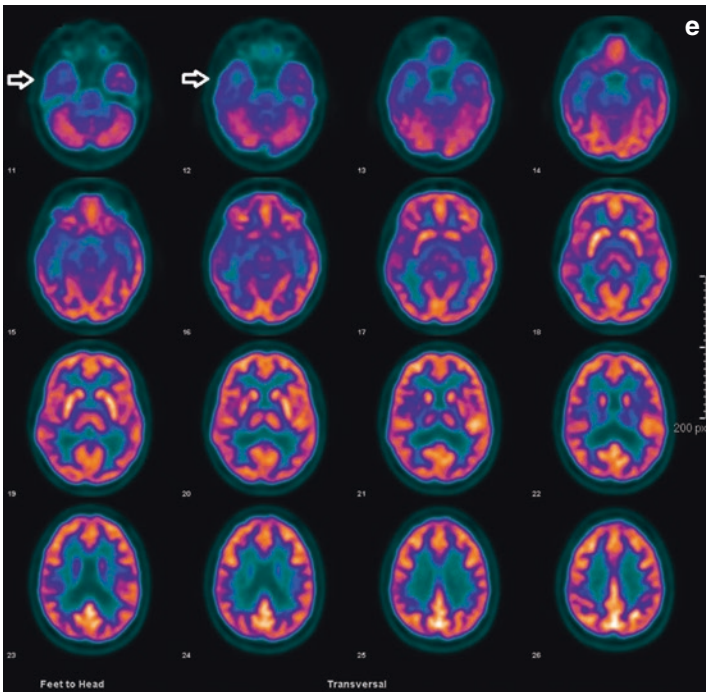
Young patient with complex partial seizure. The T2 flair and T2 axial 3T MRI (a and b) show normal appearance of both temporal lobes. Fused FDG-PET/MR and coronal and axial FDG-PET (c–e) identify reduced metabolism in the right temporal lobe (arrows), in keeping with the epileptogenic focus. This is also confirmed by Minoshima maps (f) (arrowhead) which identify spreading of the hypometabolism to the inferior surface of the right frontal lobe
